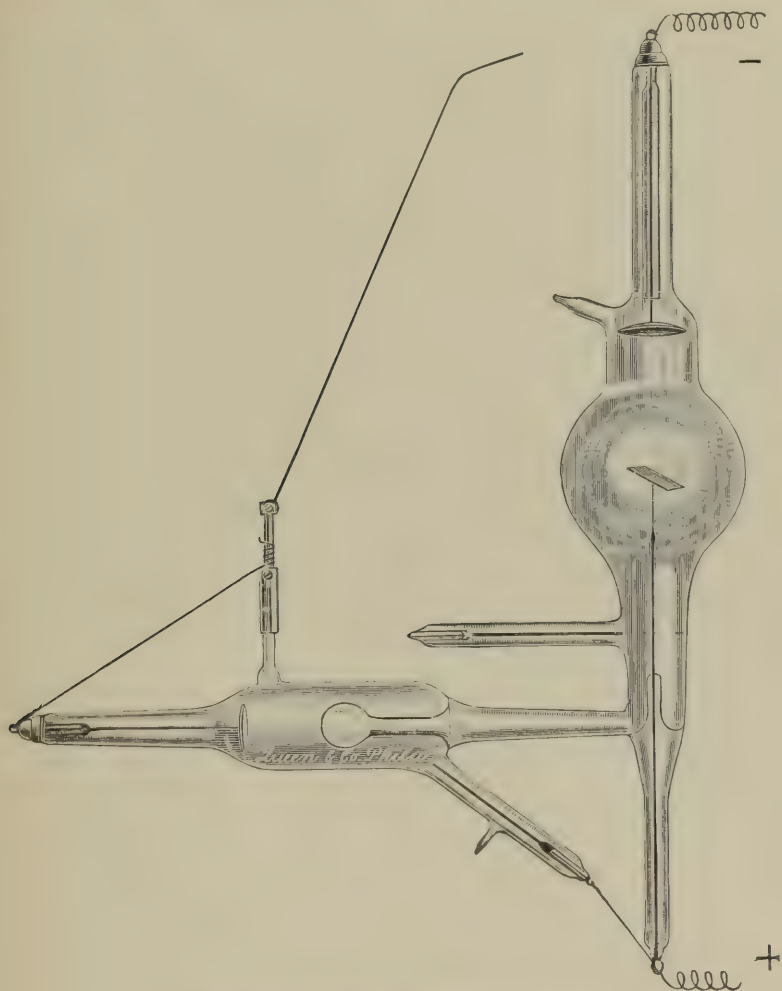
Queen self-regulating x-ray tube.
